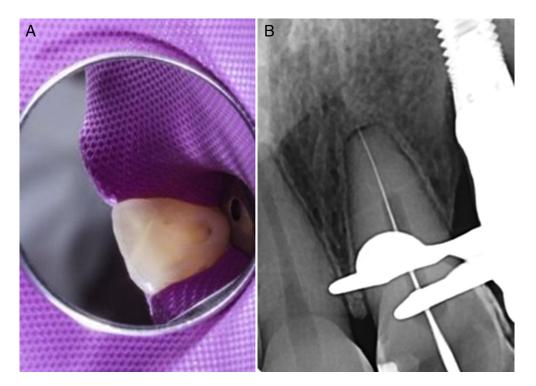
(*A*) The coronal access performed in a minimally invasive fashion preserving the incisal edge of the tooth. (*B*) A radiograph of a #10 K-type file reaching the root canal apical third with the purpose of establishing the working length.
